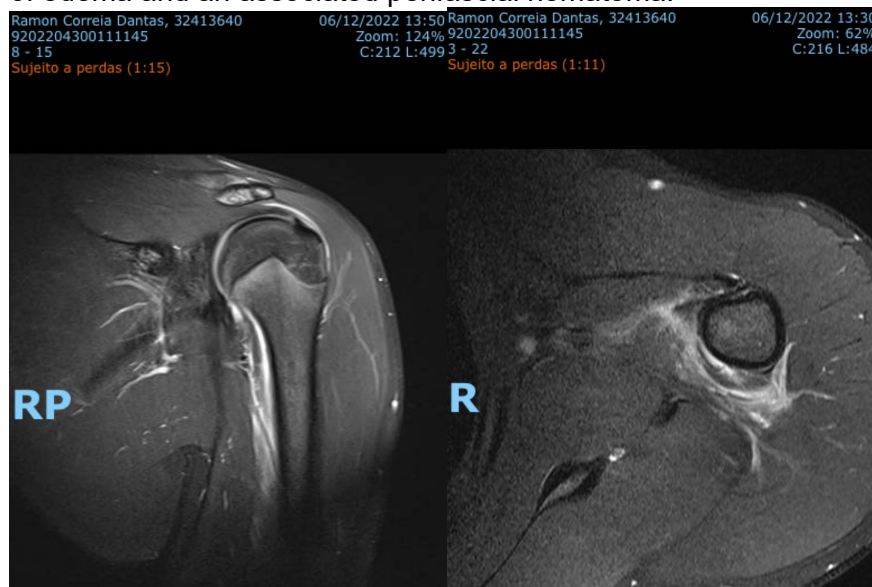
Pre-treatment MRI images of the patient
